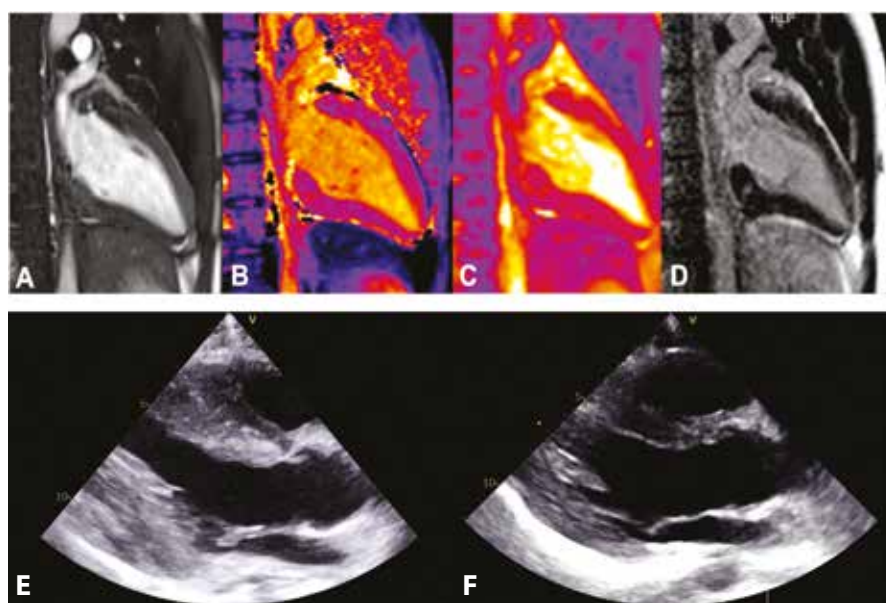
A–D. Post COVID-19 myocarditis on cardiac magnetic resonance — two-chamber images: A. cine; B. T1-mapping; C. T2-mapping; D. late gadolinium imaging. Images B–D show increased mid-wall signal in the basal inferior segment and increased subepicardial signal in the basal anterior segment. E–F. Wall thickness dimensions in the parasternal LAX view by TTE. E. Thickened LV wall (during hospitalization). F. Normal LV thickness (at discharge). The time difference between those two images is 13 days
